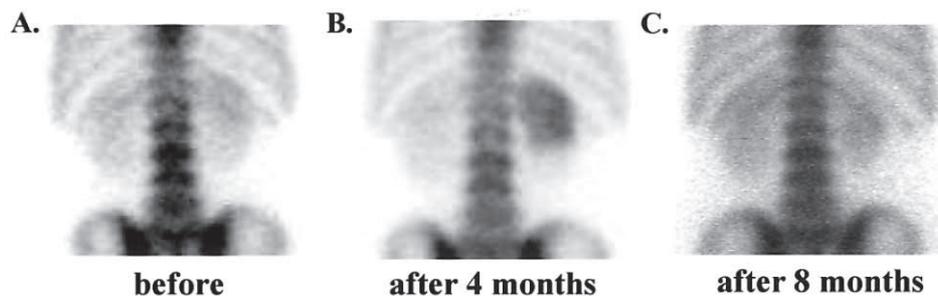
Sequential ^{99m}Tc -HMDP bone scintigraphies in Case 4. (A) Bone scintigraphy performed 10 days before radiotherapy demonstrated no abnormalities in the kidney. (B) The increased accumulation of ^{99m}Tc -HMDP was observed at the upper two-thirds of the right kidney four months after irradiation. (C) Eight months after irradiation, bone scintigraphy showed an accumulation defect at the upper part of the right kidney.
